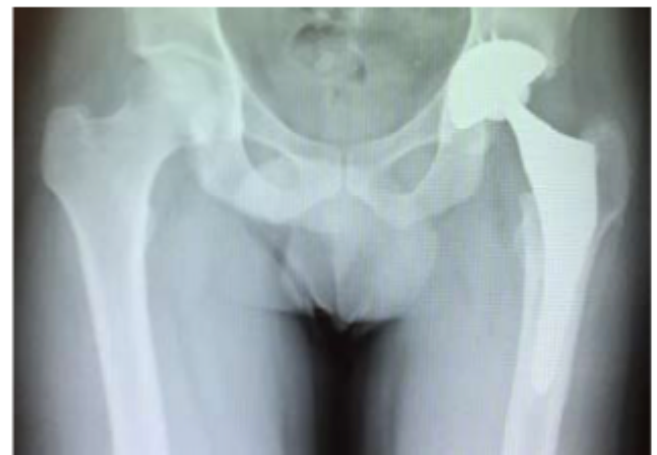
Hip X-ray in anterior-posterior projection, after total hip arthroplasty surgical treatment.
